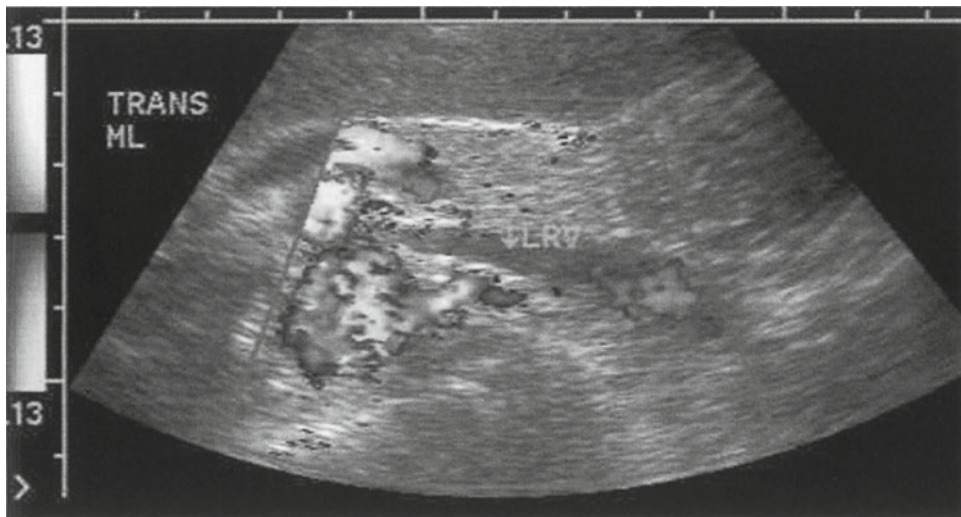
Doppler ultrasound image of an infant with left renal vein thrombosis
